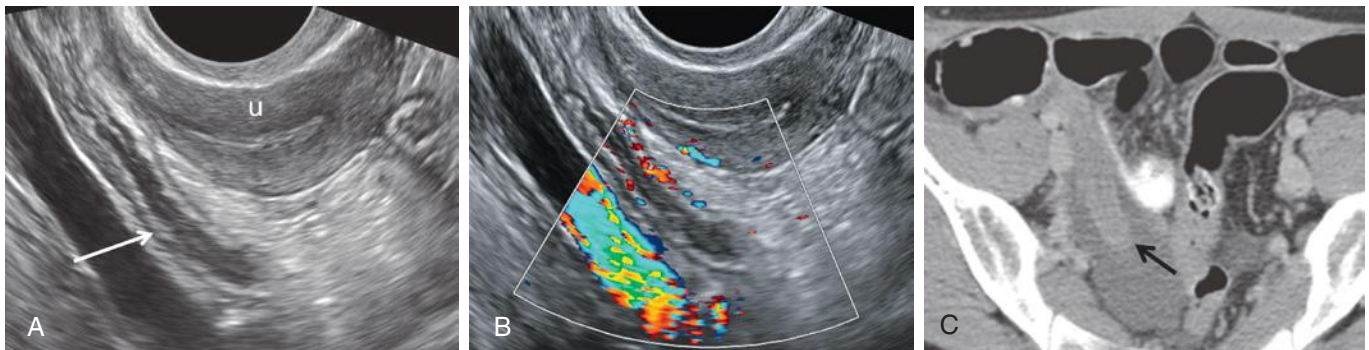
Acute appendicitis detected on transvaginal sonogram. A, Patient presented with right pelvic pain and clinically suspected adnexal disease. The tubular, blind-ending appendix is dilated and fluid-filled (*arrow*), located to the right of the uterus (*u*). B, Color Doppler sonographic image demonstrates hyperemia in the wall of the inflamed appendix. C, Acute appendicitis (*arrow*) was confirmed at computed tomography scan.
